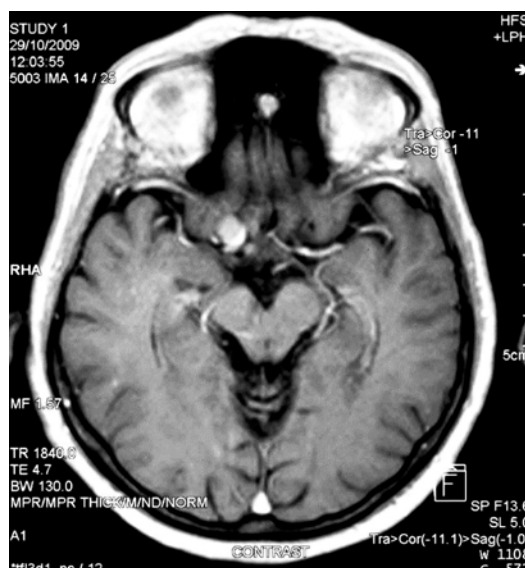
Brain magnetic resonance imaging (MRI) with focal, nodular lesion localized in the right cavernous sinus near internal carotid artery and medial cerebral artery. This lesion has MRI characteristics of granulomatous lesion.
